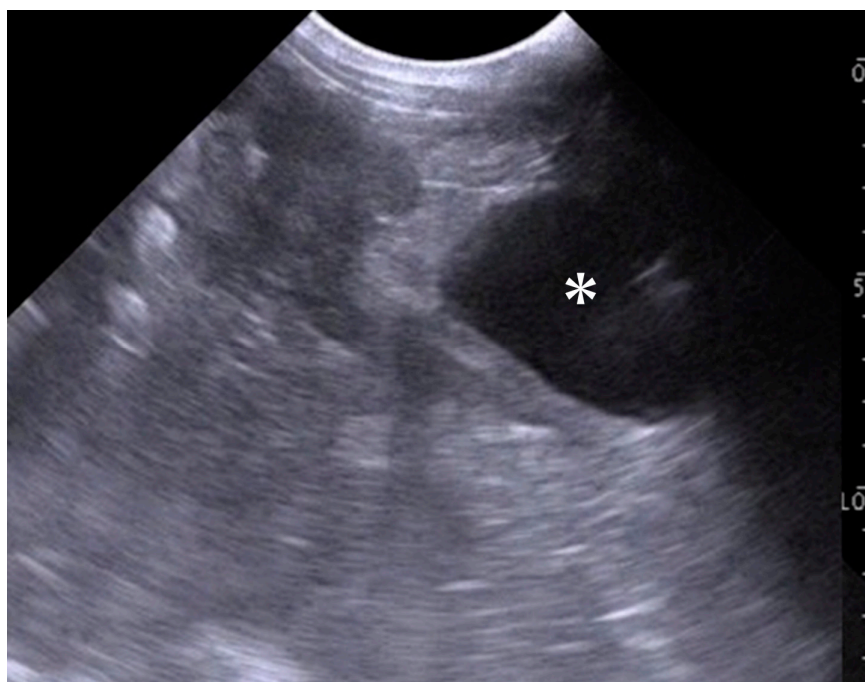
Ultrasonographic appearance of the uterus when scanning percutaneously. Anechoic fluid (asterisk) is seen within the enlarged uterine lumen. Scale = 10 mm.
